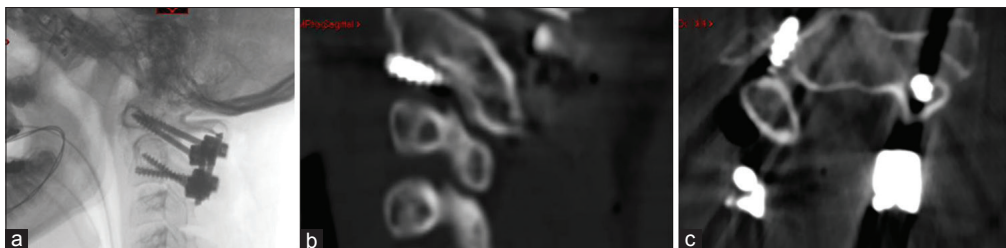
A patient undergoing C1-2 fluoroscopic-guided procedure for Os odontoid. (a) Demonstrates lateral fluoroscopic view. Post-operative CT scan reveals a malpositioned right C2 screw that was not evident on 2D fluoroscopy. Post-operative sagittal (b) and axial (c) scans demonstrate lateral and inferior screw breach (Grade 2).
